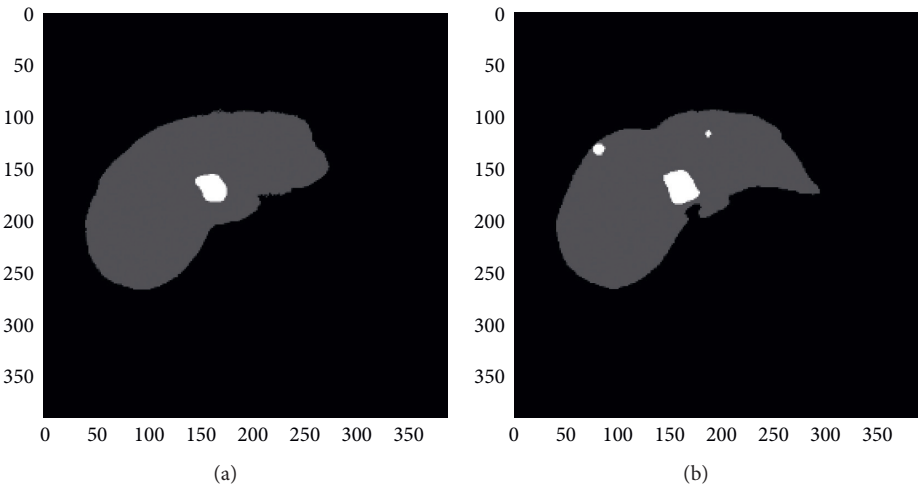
Level Set Technique with Input CT image of liver cancer cells.
